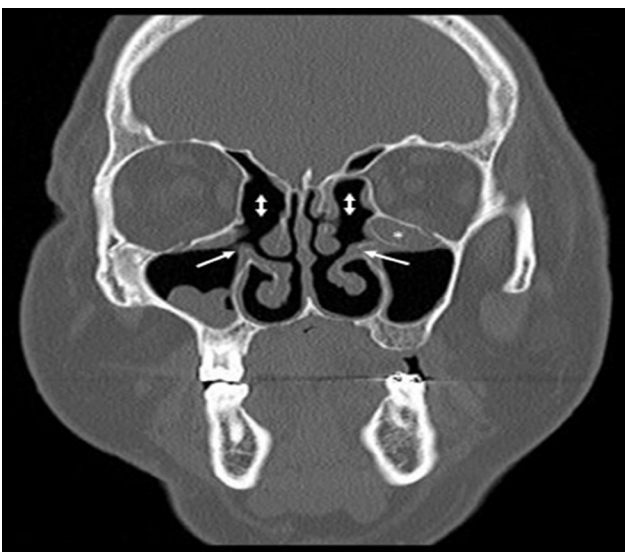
Coronal CT image shows bilateral uncinectomies (arrows) and ethmoidal bullectomies (two head arrows), mucosal disease in maxillary sinus and left Haller cell (asterisk).
